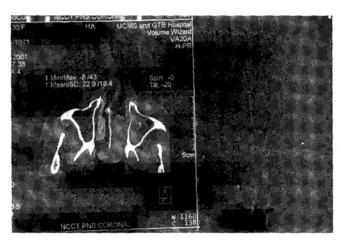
CT Scan—Axial cut of Antrochoanal Polyp.
